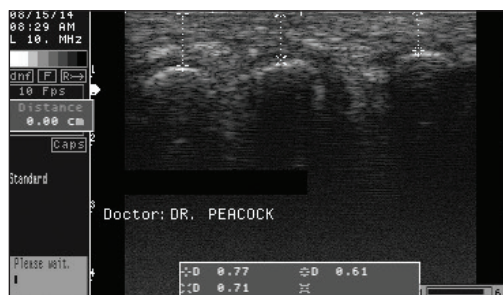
Ultrasound view intra-operatively following lesser 2nd, 3rd, and 4th metatarsal osteotomies
